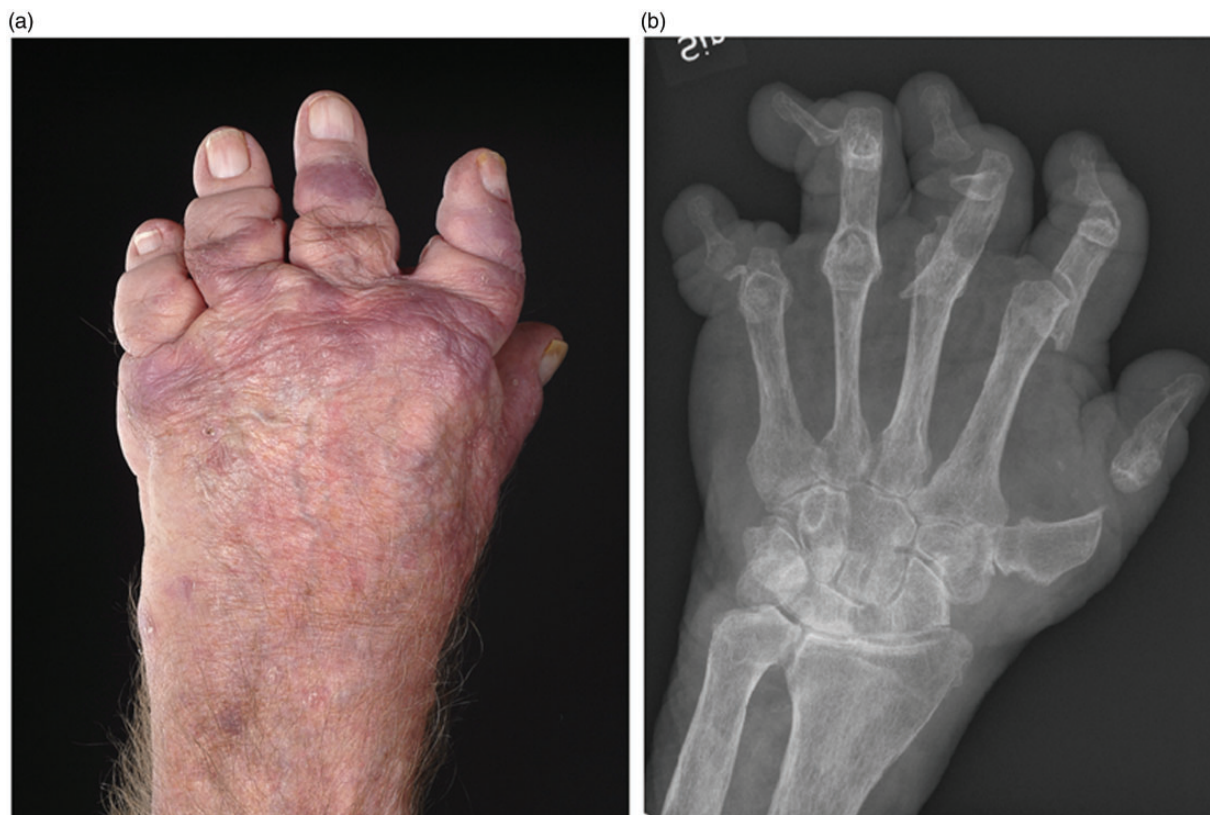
A 66-year-old man with a 32-year history of PAM. His hands show classical sign of severe PAM deformity with shortening or digital telescoping of his fingers with flail joints (left), and the radiograph (right) shows profound osteolysis in several joints and pencil-in-cup deformities (MCP IV) of his hand with relative sparing changes of his wrists and no sign of ankylosis. PAM, psoriatic arthritis mutilans.
